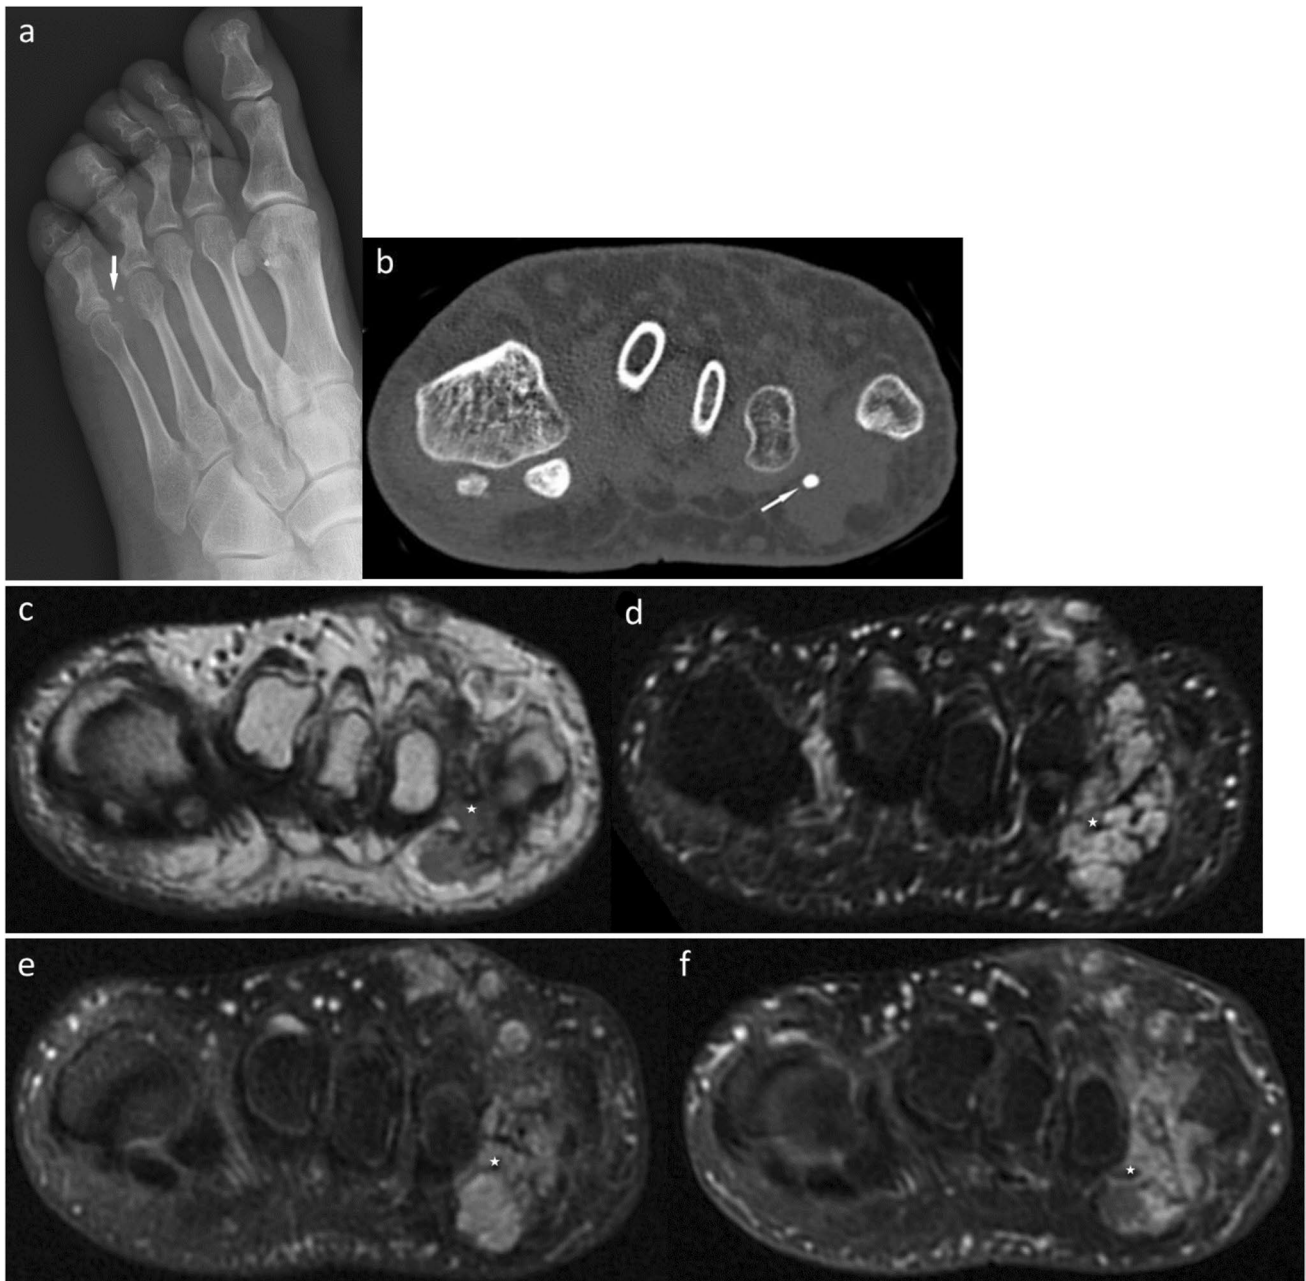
A 47-year-old man with slow flow vascular malformation. a Left foot oblique radiograph shows a calcific focus compatible with a phlebolith projected over the 4th web space. b Coronal CT confirms a subcutaneous lobulated lesion with an internal phlebolith in the 4th web space without any bony erosion. c, d Coronal T1-weighted image (c) and coronal short tau inversion recovery (STIR) image (d) shows a lobulated STIR hyperintense lesion (star) involving the lateral
